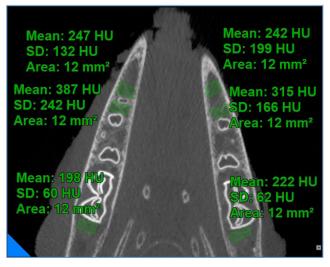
Axial section of the CBCT scan of sample II indicating multiple placements of regions of interest (ROI)
